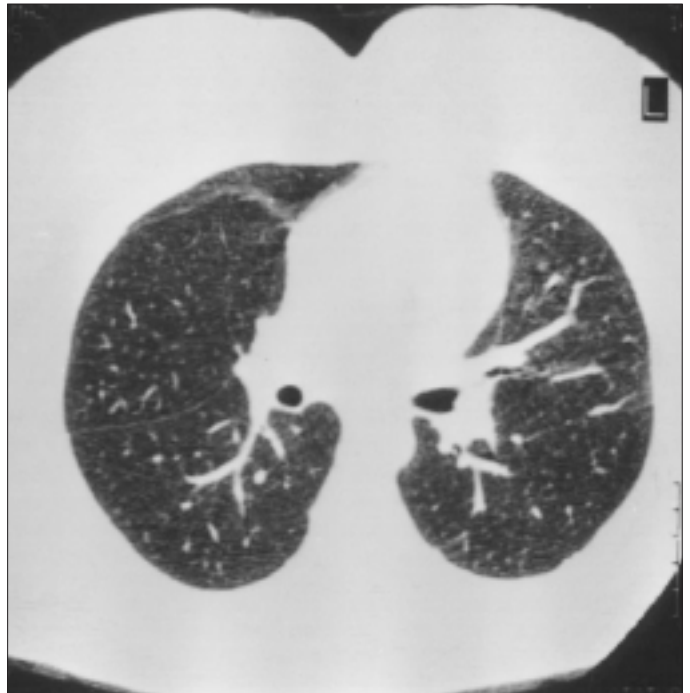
Thorax CT of the case 1
